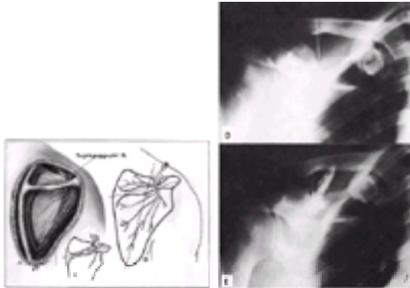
Suprascapular nerve block. A: Anatomy of the suprascapular nerve. B: Needle placement: After identifying the spine of the scapula, a line is drawn on the skin overlying it, with another line bisecting the inferior angle of the scapula (*dashed lines*). The outer triangle formed by the two intersecting lines is bisected and a wheal is formed on this line, about 1.5 cm from the angle. An 8-cm, 22-gauge needle is introduced through this wheal so that its shaft is directed anteriorly and slightly caudad and mesiad to make contact with the supraspinatus fossa just lateral to the suprascapular notch. The needle is withdrawn until its point is in the subcutaneous tissue and reintroduced so that its point is directed 5 mm medial to the point of first contact. Advancing the needle in this direction usually causes its point to enter the notch, make contact with the nerve, and elicit paresthesia. C: If the second insertion fails to produce paresthesia, a third or fourth insertion is made in search of the notch. Usually 3 to 5 mL of a local anesthetic solution produces block of the nerve. The radiographs show the point of the needle in the suprascapular notch before (D) and after (E) injection of 3 mL of 30% Diodrast. Note the diffusion of the dye.
